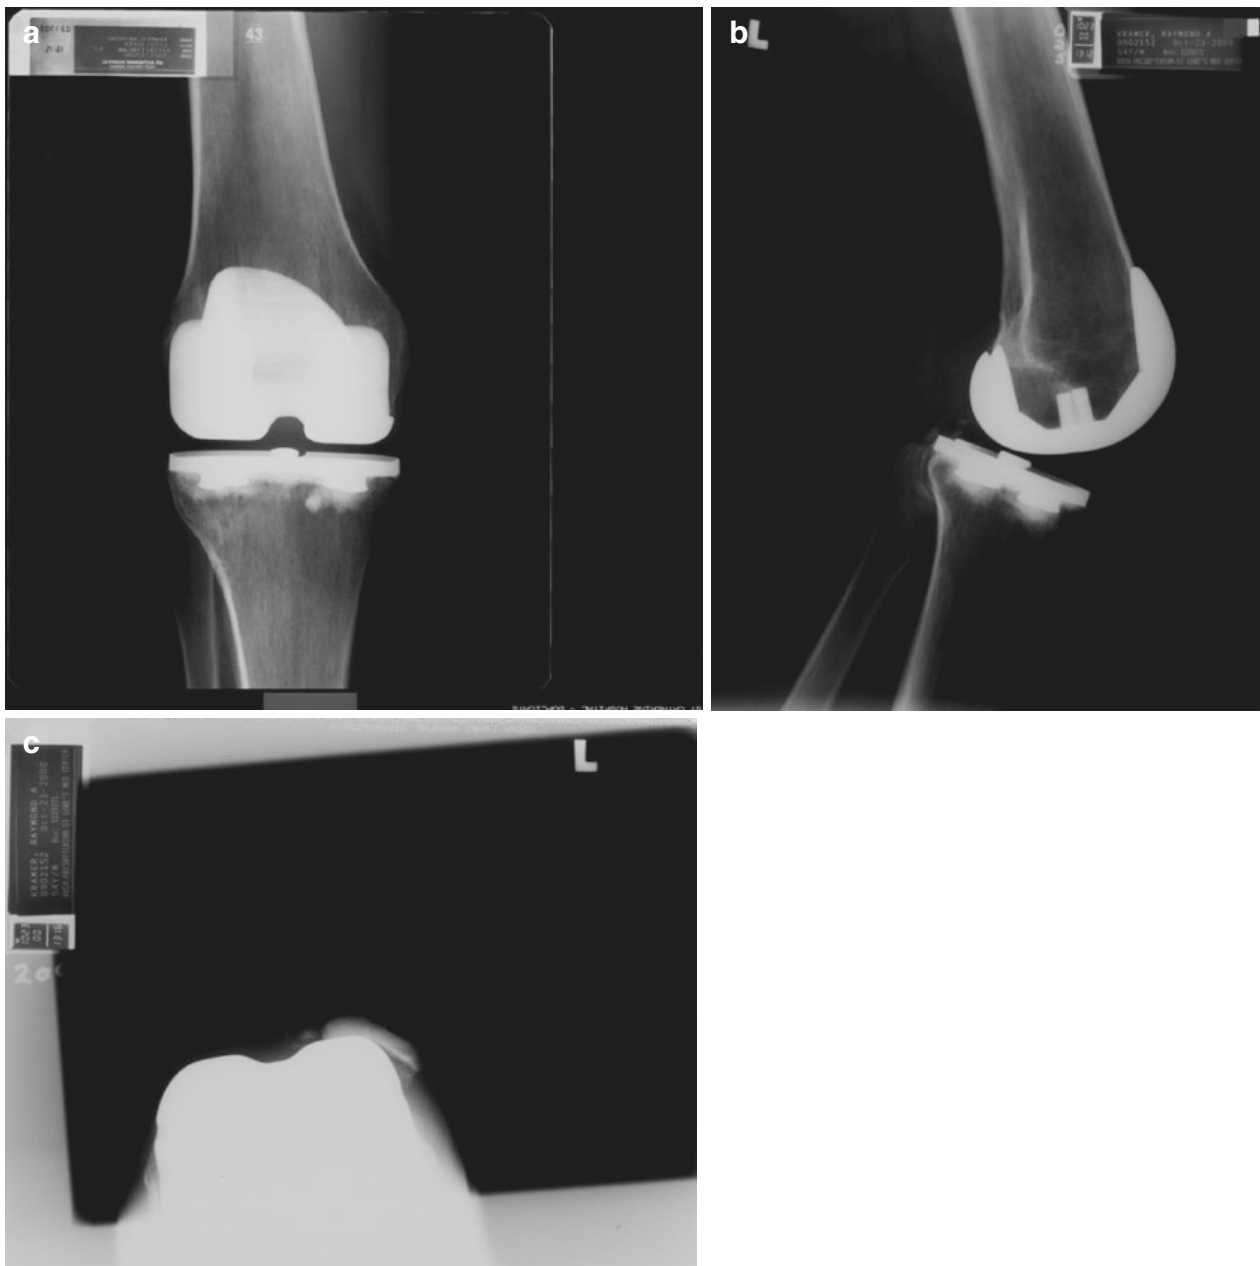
Plain radiographs of the knee, including (a) anteroposterior, (b) lateral, (c) and skyline views, revealed a well-fixed cemented total knee arthroplasty. The patella was sclerotic, and there was no evidence of a patellar
